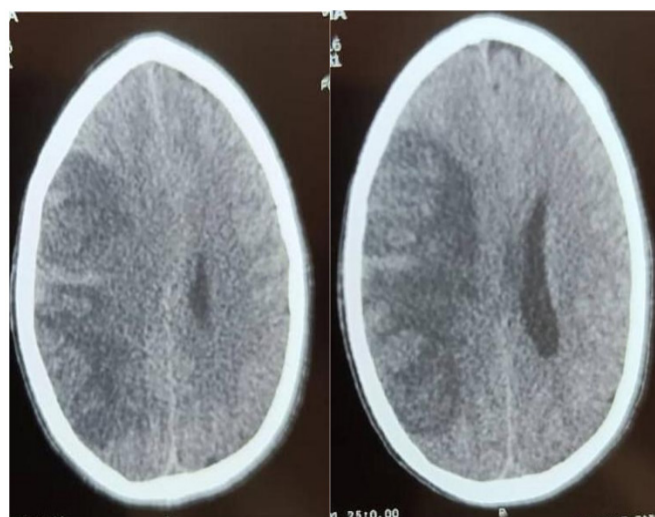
Cerebral computed tomography images of the patient's lesions
